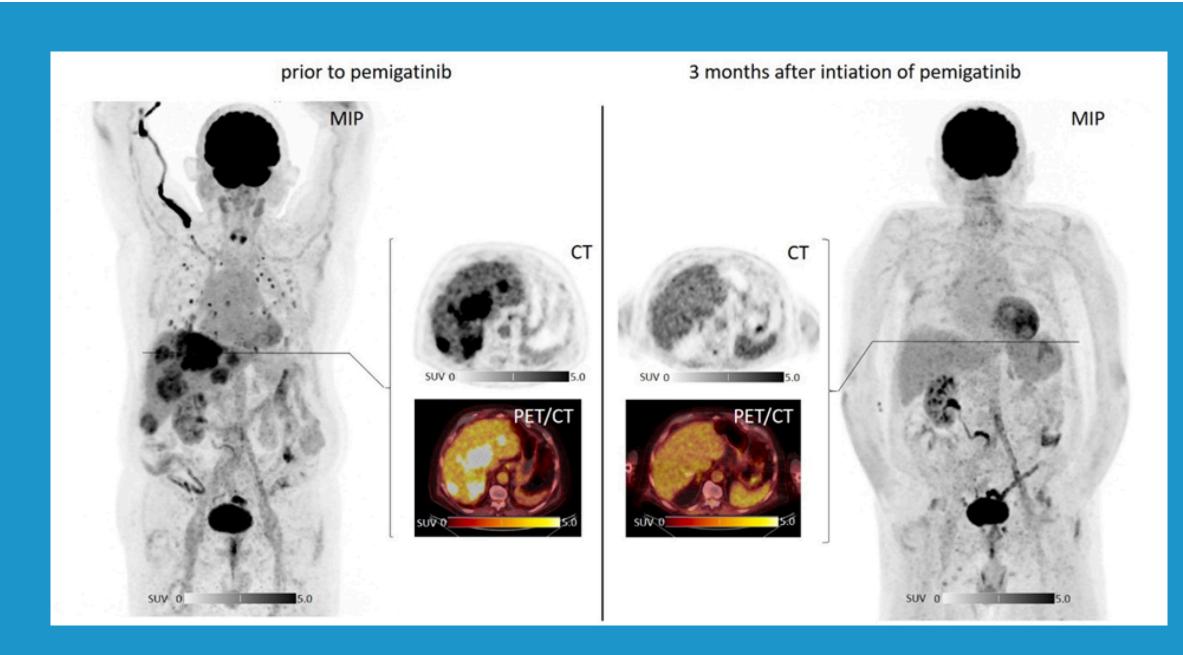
Display of complete metabolic remission three months after initiation of pemigatinib. Given are maximum intensity projections (MIP; outer columns) as well as transaxial slices of computed tomography (CT, inner upper column) as well as fused positron emission tomography/computed tomography (PET/CT; inner lower column). While the patient initially presented with multiple pulmonary as well as hepatic metastases, follow-up imaging revealed complete metabolic resolution of all lesions.
